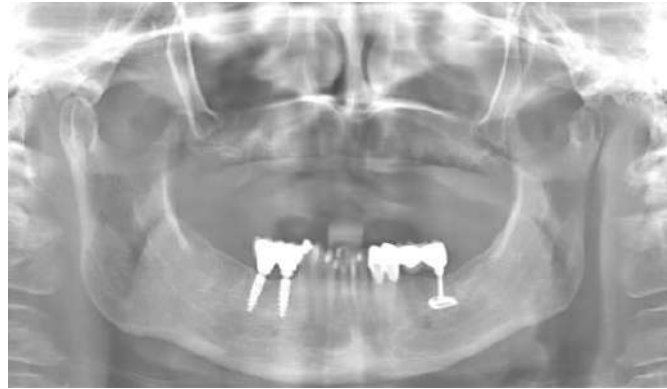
shows the panoramic radiograph of the patient at presentation.
